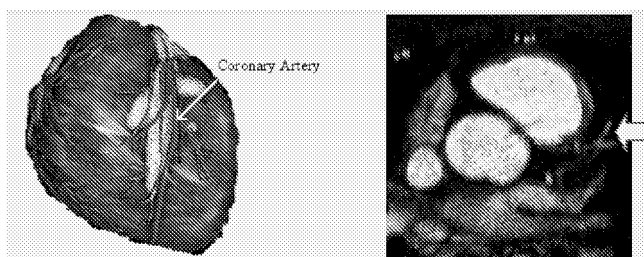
A 3D view of the human heart (left, source: Coronary Artery Surgery Forum) and one slice of the MR image (right, source: FIT).
